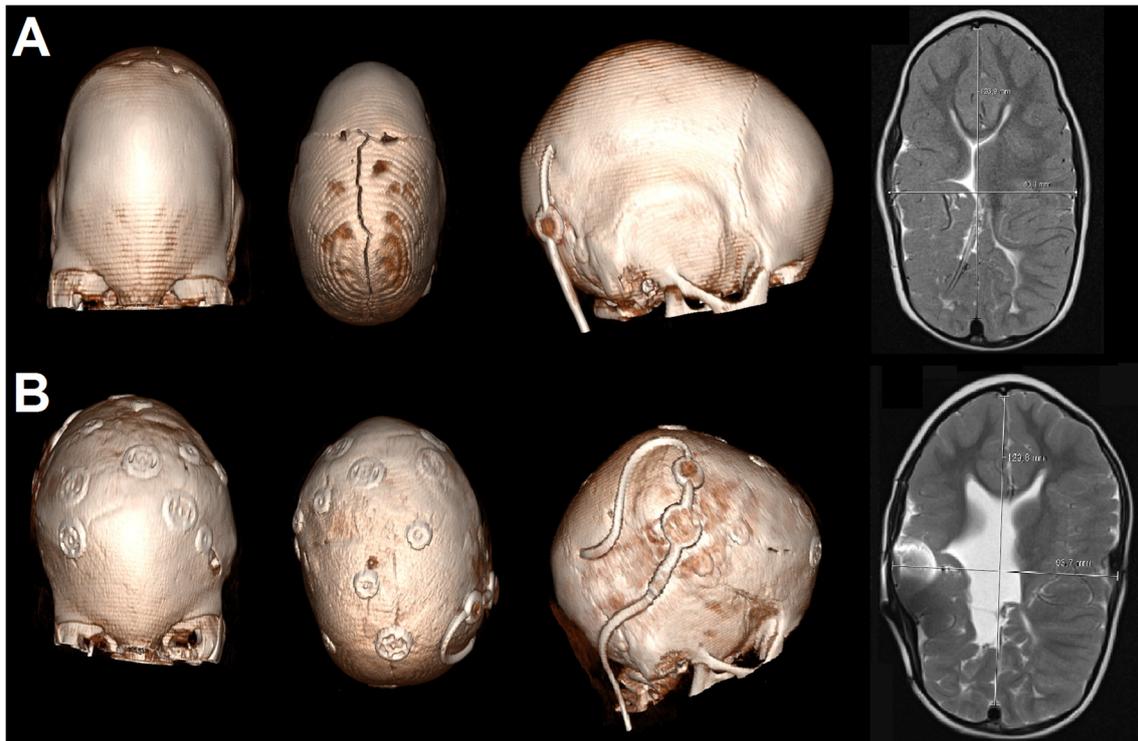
Cranial MRI of a child with CCD showing a dolichocephalic head shape and slit ventricles before surgery (a) and an improvement of cephalic index and ventricular size after cranial expansion surgery (b)
